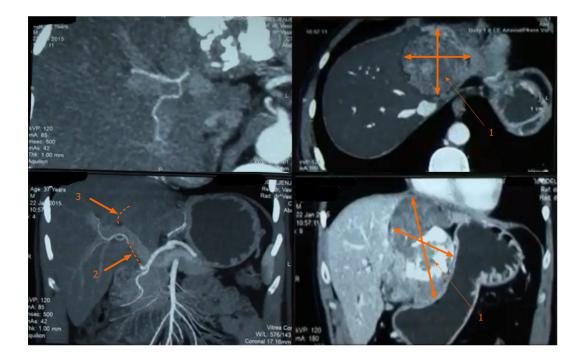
Multi-detector computed tomography of the abdomen. 1: Tumor; 2: Infiltration of proper hepatic artery from the origin of the gastro-duodenal aretry up to the right second branching 3-complete infiltration of the left portal vein.
